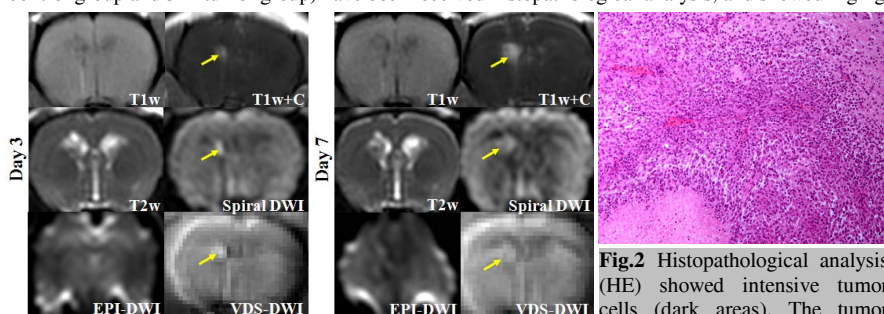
By using traditional MRI protocol, no clear mass can be found, whereas an increasingly enlarged mass was successfully depicted by multi-parametric MRI sequences (yellow arrows).
